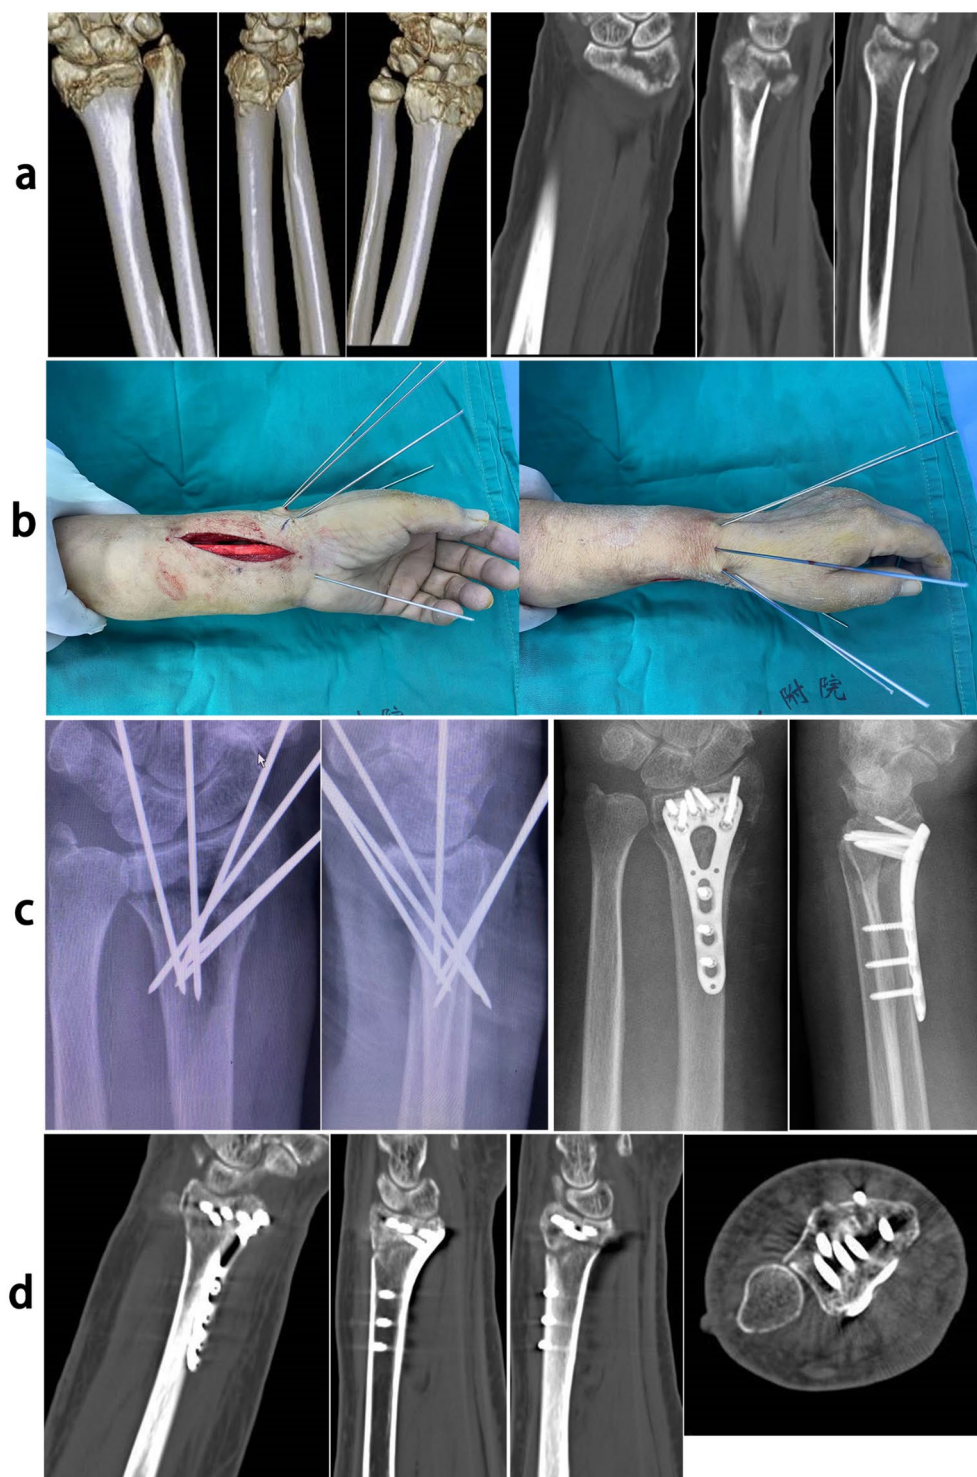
a: preoperative wrist CT examination; b: image of multi-direction temporary Kapandji pinned technique; c: radioraphy on wrist of multi-direction temporary Kapandji pinning and volar locking plate; d: postoperative review wrist CT
